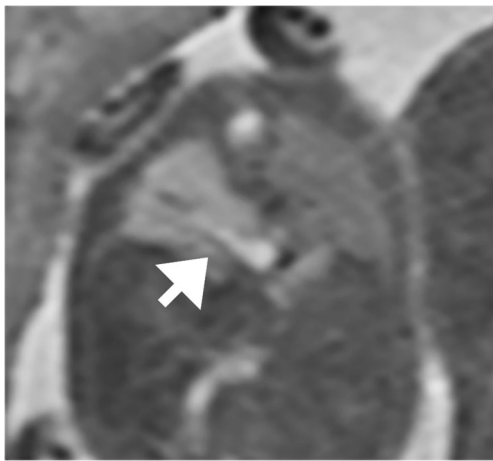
Esophageal bronchus. Coronal single-shot turbo spin-echo (SSTSE) MR image in a 22-week fetus demonstrates a T2-hyperintense bronchocele (*arrow*) directed toward the stomach, rather than the bronchial tree, consistent with an esophageal bronchus
